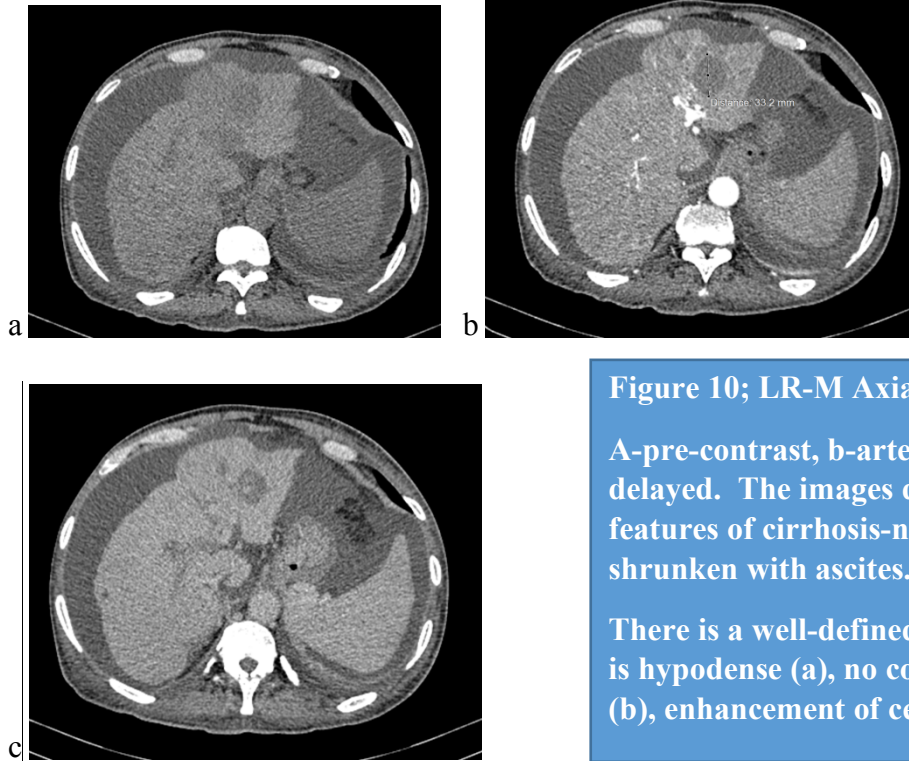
LR-M Axial CT scan images
